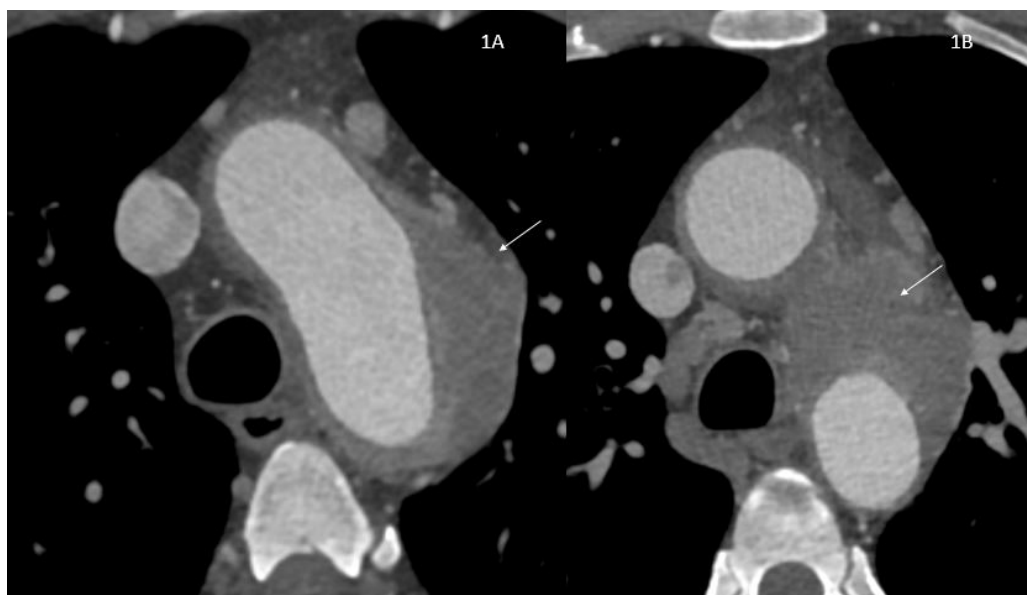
Case 1. Axial computed tomography image shows periaortic soft tissue lesion indicated by white arrow
